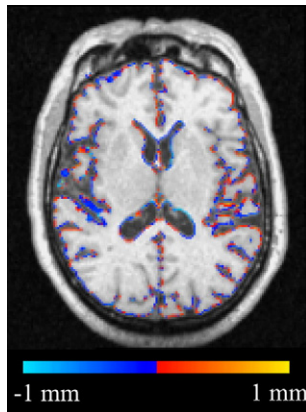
Example of an edge-displacement map of a 66-year-old patient with type 2 diabetes with mild cognitive impairment overlaid on the baseline axial MR image. Time between baseline and follow-up MR scans was 1 year and 5 months. Estimated rate of atrophy was $-1.4\%/year$. Dark-blue to light blue represents mild to severe local contraction, which implies atrophy. Red to yellow indicates mild to severe local expansion of brain tissue. Note that for display purposes, edge motion was truncated at 1 mm in this figure. Image courtesy of Dr. J.D. Sluimer, VU University Medical Center, Amsterdam, The Netherlands.
